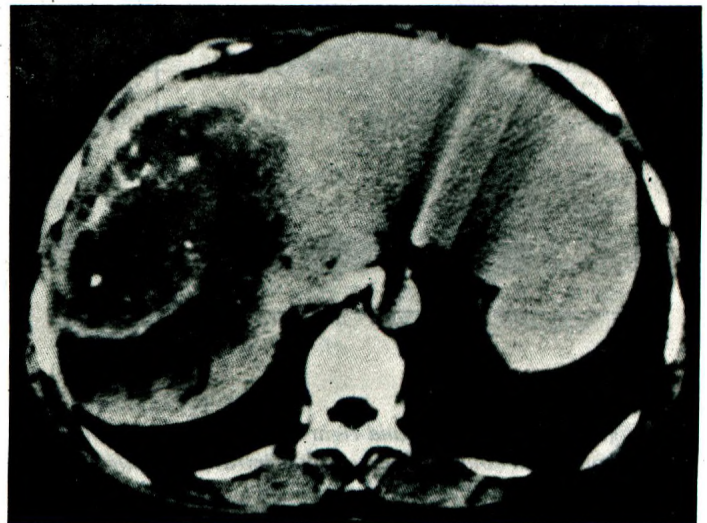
CT scan of the abdomen demonstrating a large heterogeneous, hypodence solid mass with irregular boundaries and calcified areas on the right lobe of the liver.
